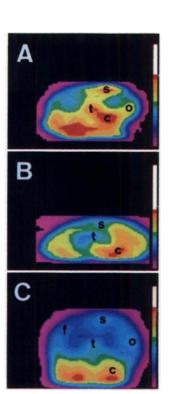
(A) Mediosagittal SPECT slice in a 41-wkold neonate with normal neurological follow-up. Tracer uptake is prominent in cerebellar (C) and thalamic (T) areas, whereas cerebral cortical areas are poorty visualized, with the exception of sensorimotor (S) and occipital (O) regions. (B) Medio-sagittal <sup>99m</sup>Tc-HMPAO brain SPECT slice in a 42-wk-old neonate who later suffered from moderate spastic quadriplegia. When compared to cerebellar (C) tracer uptake, there is marked thalamic (T) and sensorimotor (S) hypoactivity. (C) Mediosagittal <sup>99m</sup>Tc-HMPAO brain SPECT slice in a 44-wk-old neonate who later suffered from severe spastic quadriplegia. When compared to cerebellar (C) tracer uptake, there is a marked decrease of activity in the thalamic (T) and overall cerebral cortical areas (F = frontal; S = sensorimotor; O = occipital).
